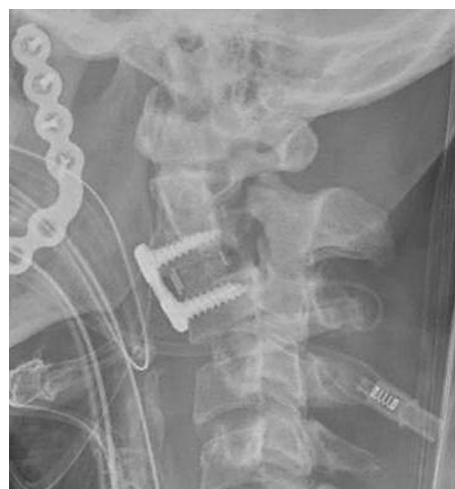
Sagittal X-ray following ACDF C2–C3 demonstrating 6.1 mm displacement
